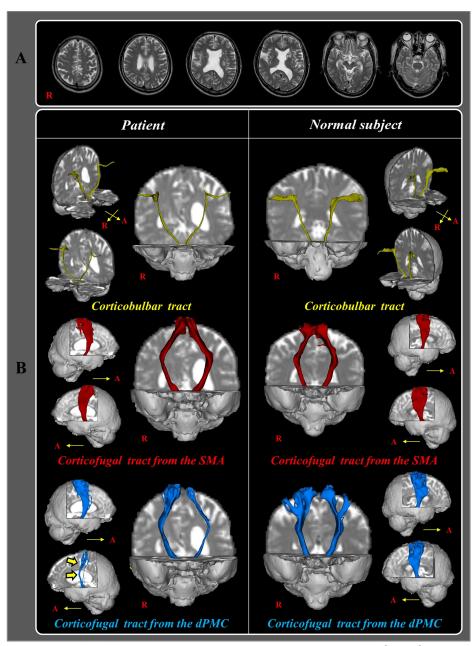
T2-weighted brain magnetic resonance images at one week after infarct onset show leukomalactic lesions in the left striatocapsular region.
